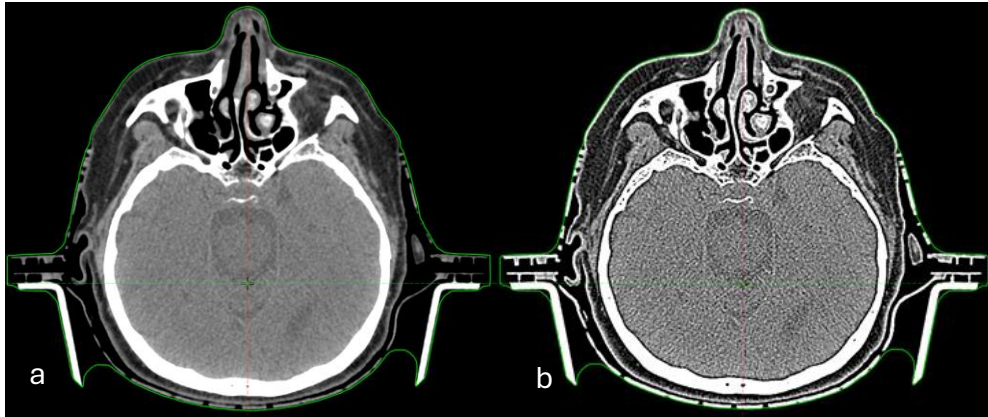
(Color online) Visual difference between CT acquisition with Standard algorithm (a) and with Lung algorithm (b)
